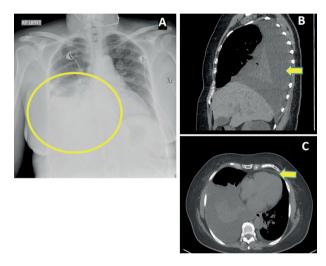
A: Chest radiograph showing right sided pleural effusion and enlargement of cardiac silhouette. B: Coronal view of computed tomography chest showing pleural effusion. C: Transverse view of CT chest showing both pleural and pericardial effusion
